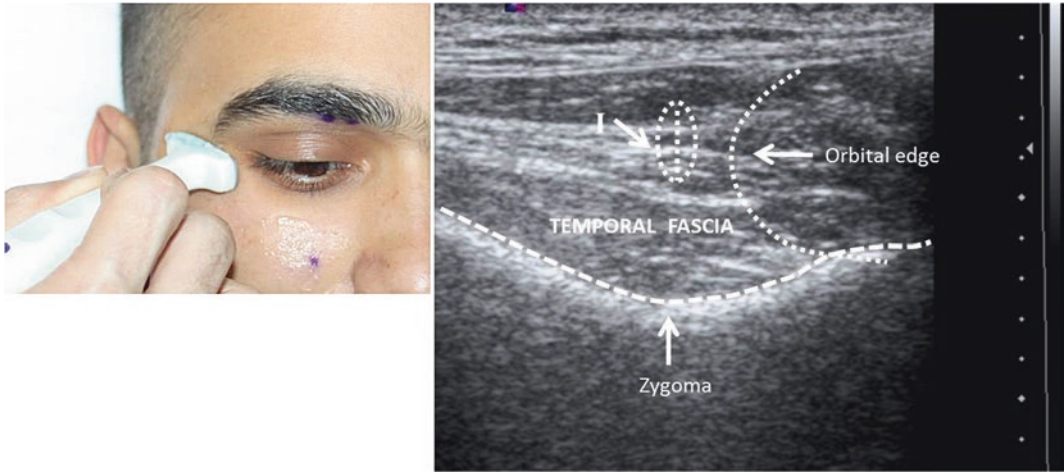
Ultrasound image for zygomaticotemporal nerve block. I: The zygomaticotemporal nerve block LA injection site
